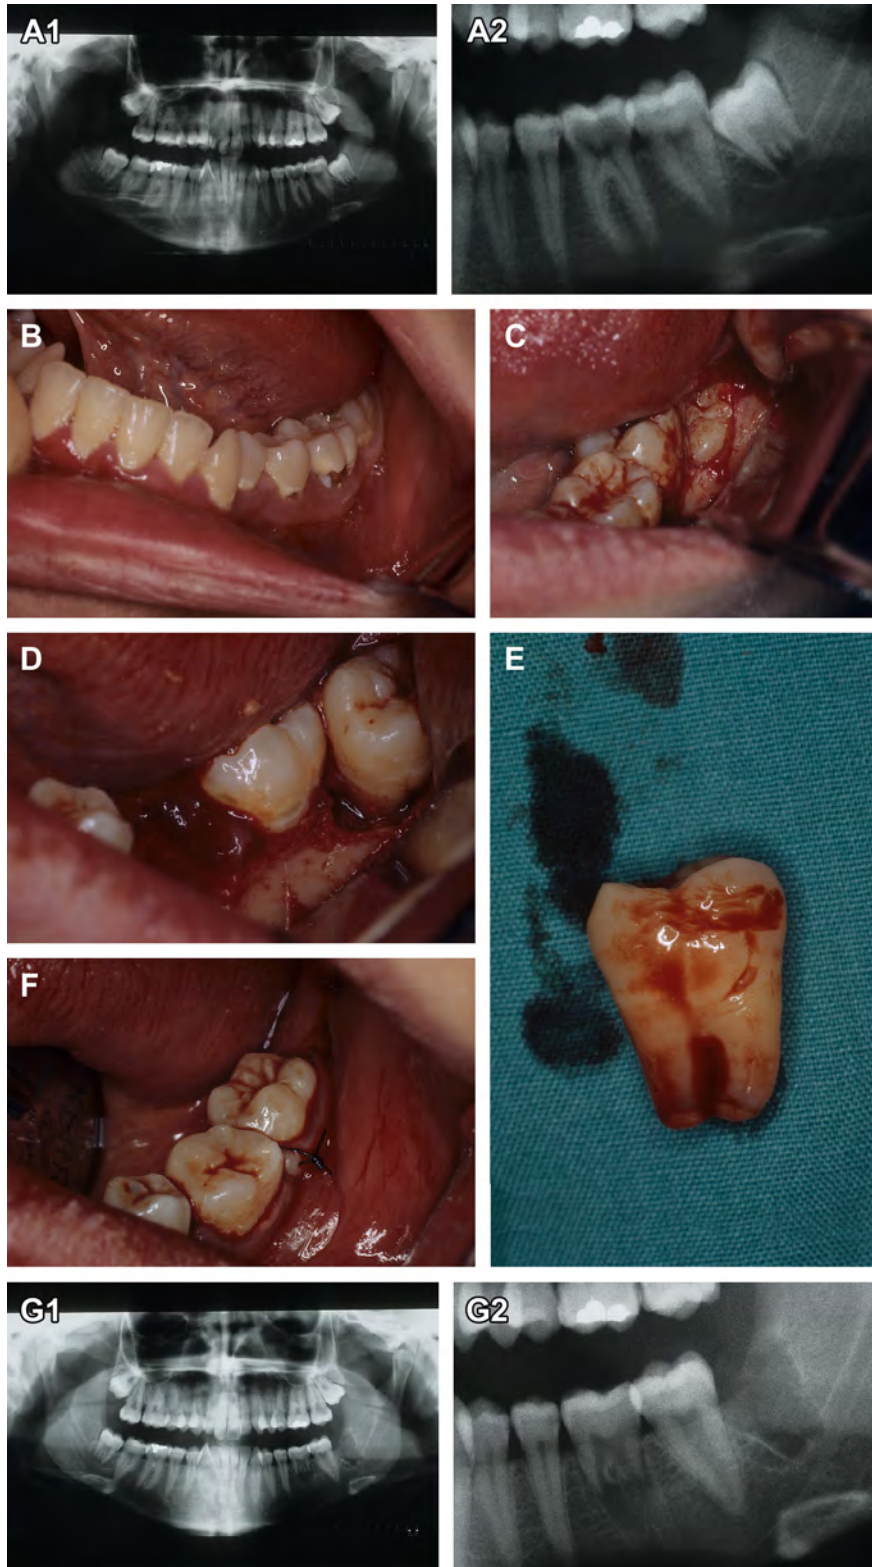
(A) Radiograph of carious, nonrestorable #19, and impacted #17 with partial root formation. (B) Photo of carious, non-restorable #19. (C) Surgical access to #17. (D) #19 Removed with 23 forceps and #17 elevated and removed from socket. (E) #17 Transplant. (F) #17 Transplanted to site #19. (G) Radiograph post-transplantation of #17.
